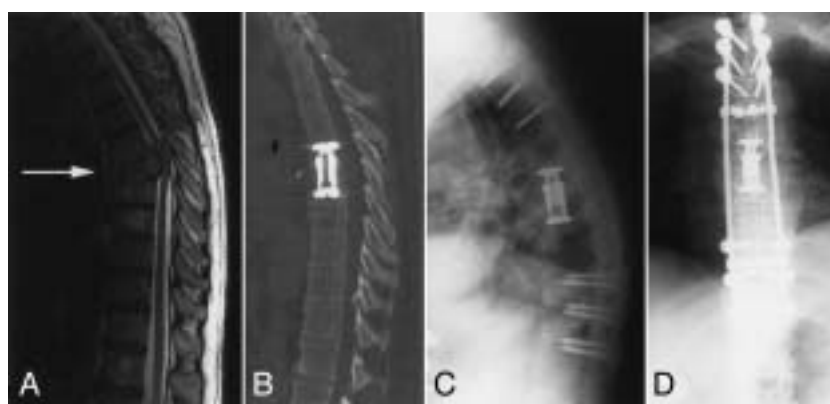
A 67-year-old man with a history of hyperthyroidism and coronary artery disease presented with sudden onset of interscapular back pain and gait disturbance. The patient had upper motor neuron type weakness in bilateral lower limbs. A preoperative sagittal T2-weighted magnetic resonance image (A) shows a T7 burst fracture associated with marked narrowing of the spinal canal (arrow); T7 corpectomy through left thoracotomy was performed. Postoperative computed tomogram with sagittal reconstruction (B) shows a titanium implant (Synex cage, Synthes, Inc, West Chester, Pa) in place. Postoperative plain radiographs (C and D) show the posterior fusion from T2 through T12 performed in a second staged operation. The pathology was metastatic renal cell carcinoma.
